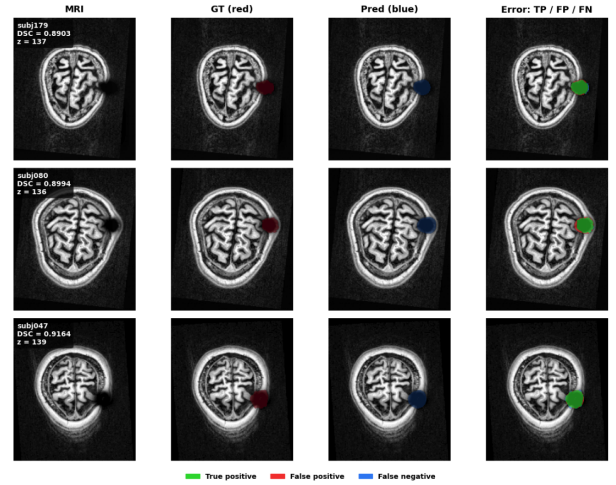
Task A validation results for three subjects. Columns show axial MRI slice, ground-truth artifact mask (red), predicted artifact mask (blue), and error map with true positive, false positive, and false negative regions.
